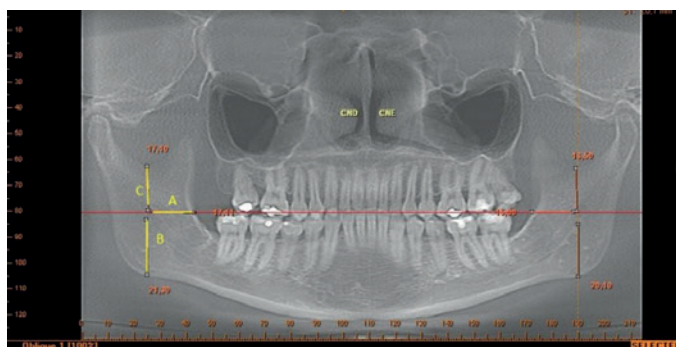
CBCT scan panoramic view, showing points A, B and C.
